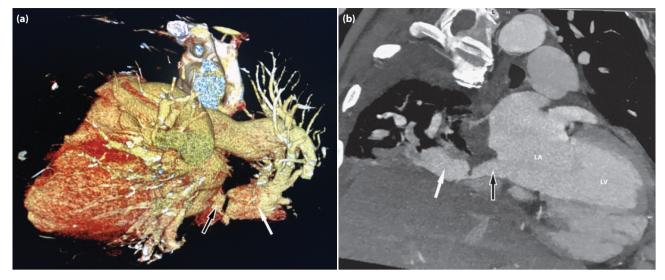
Scimitar syndrome in a 56-year-old male: (a) Volume rendering (VR) reformatted computed tomographic (CT) image showing the anomalous pulmonary vein (white arrow) and the baffle (black arrow). (b) Multiplanar reconstruction (MPR) CT image showing the anomalous pulmonary vein (white arrow) and the baffle (black arrow). LA: Left atrium, LV: Left ventricle.
